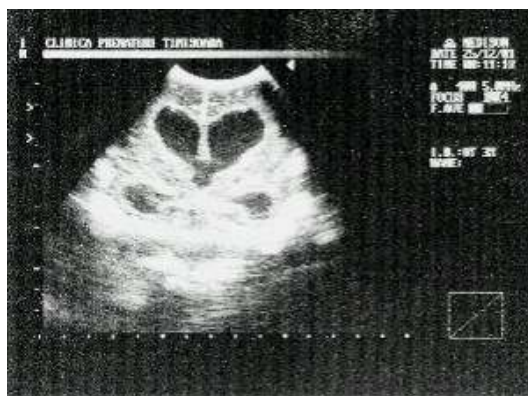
Transfontanellar ultrasound – no sings of intraventricular hemorrhage.
